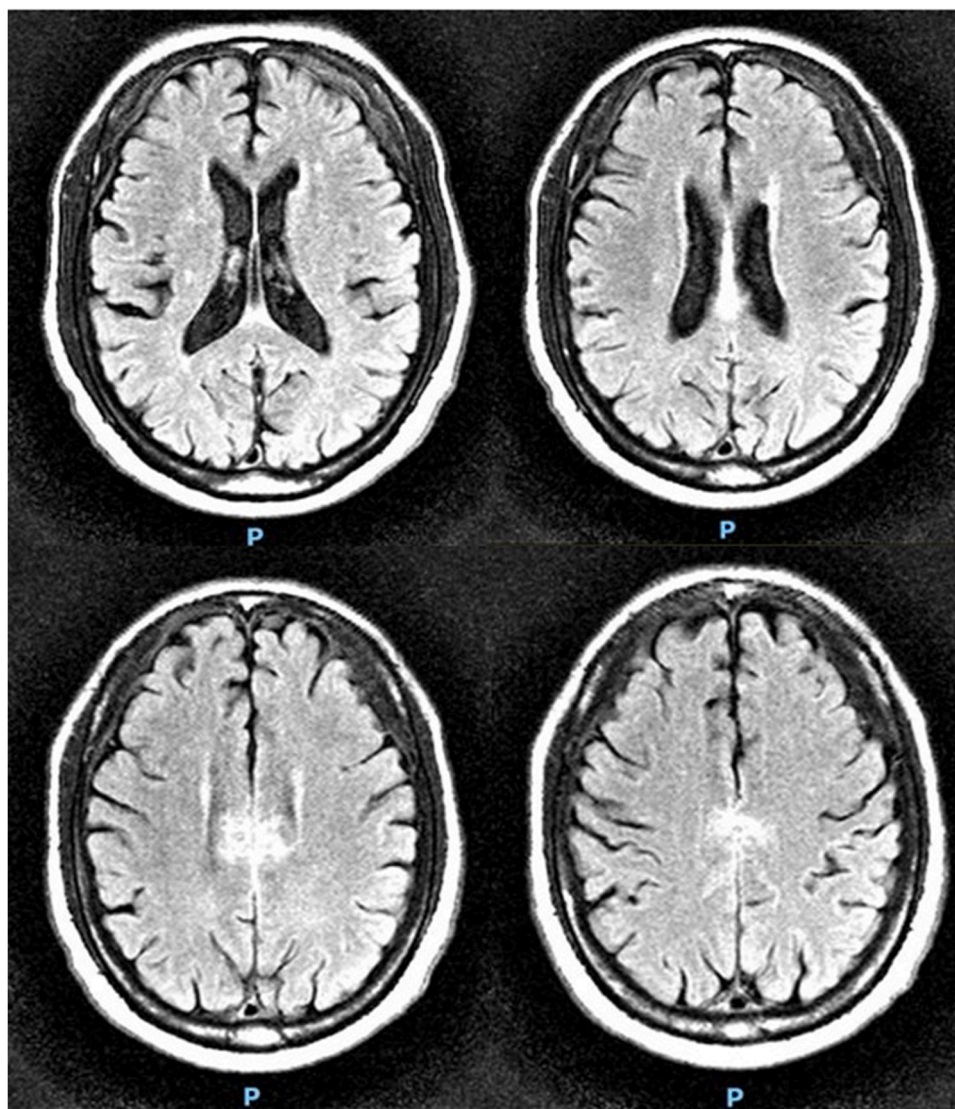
MRI brain with and without IV contrast shows interval changes with improvement of the enhancing abnormalities.
